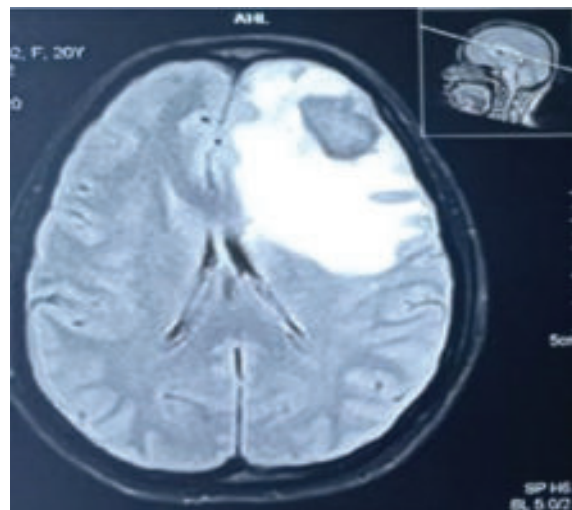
MRI Flair the axial plane shows massive perilesional edema. Effacement of the ipsilateral lateral ventricle, obliteration of sulci/gyri demarcation, and midline shift
